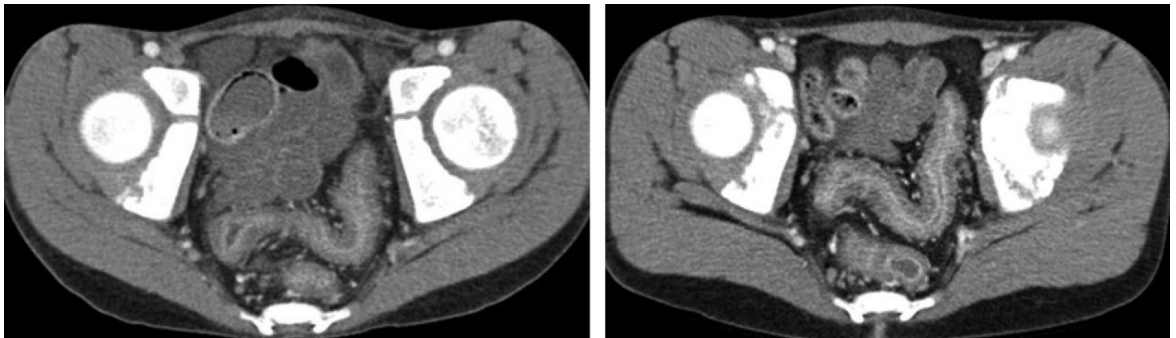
Improved contrast enhancement at a lower tube voltage in an 11-year-old boy. Two CT examinations were performed in a 4-month interval, one at 120 kV with a $CTDI_{vol}$ of 5.18 mGy (a) and the other at 100 kV with a $CTDI_{vol}$ of 3.98 mGy (b), following a 50-second delay after contrast material injection. The 100 kV image shows improved contrast enhancement and visualisation of mural stratification [2]
